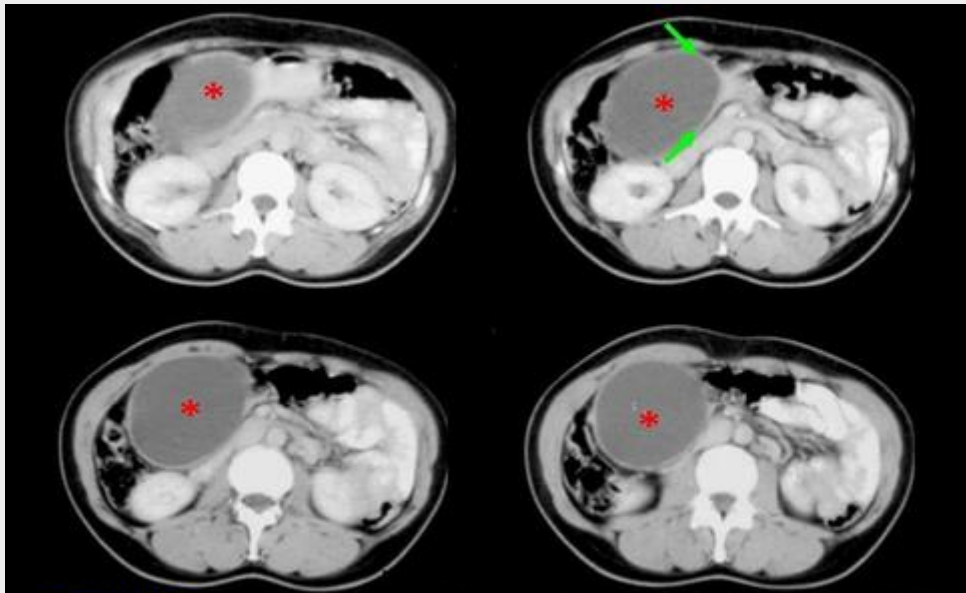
Duplication cyst of the gastric antrum. Post-contrast CT images show a fluid-attenuation well-defined oval mass with a thick regular wall located in the anterior wall of the gastric antrum (*). Note the obtuse angles between the lesion and the gastric wall (→).
